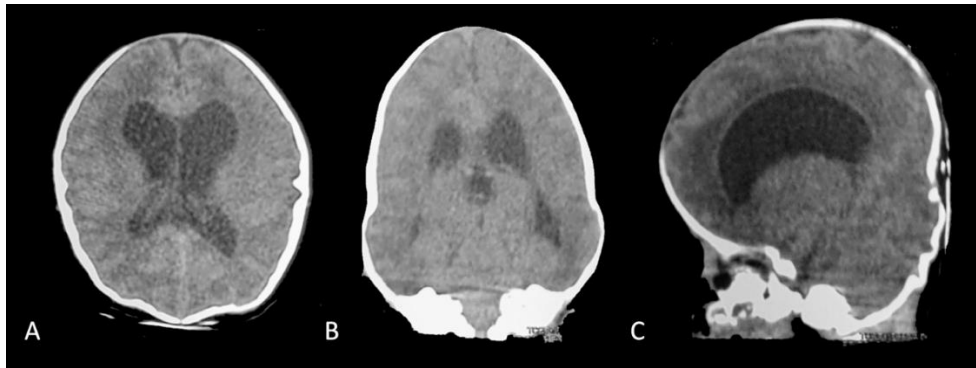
CT-scan showed craniostenosis on axial (A), coronal (B) and sagittal view (C) with ventriculomegaly suggesting hydrocephalus.
